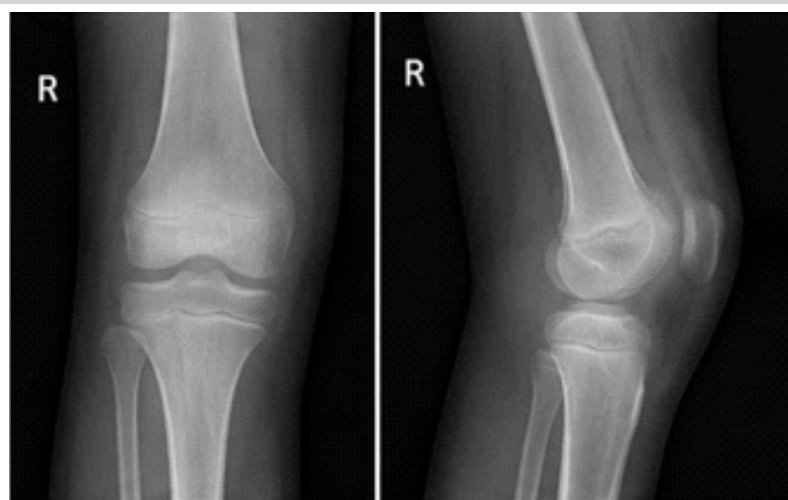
Follow-up radiographs (anteroposterior and lateral views) of the right knee at 6 months showing normal alignment, no joint space narrowing, and preserved epiphyseal growth plate.
